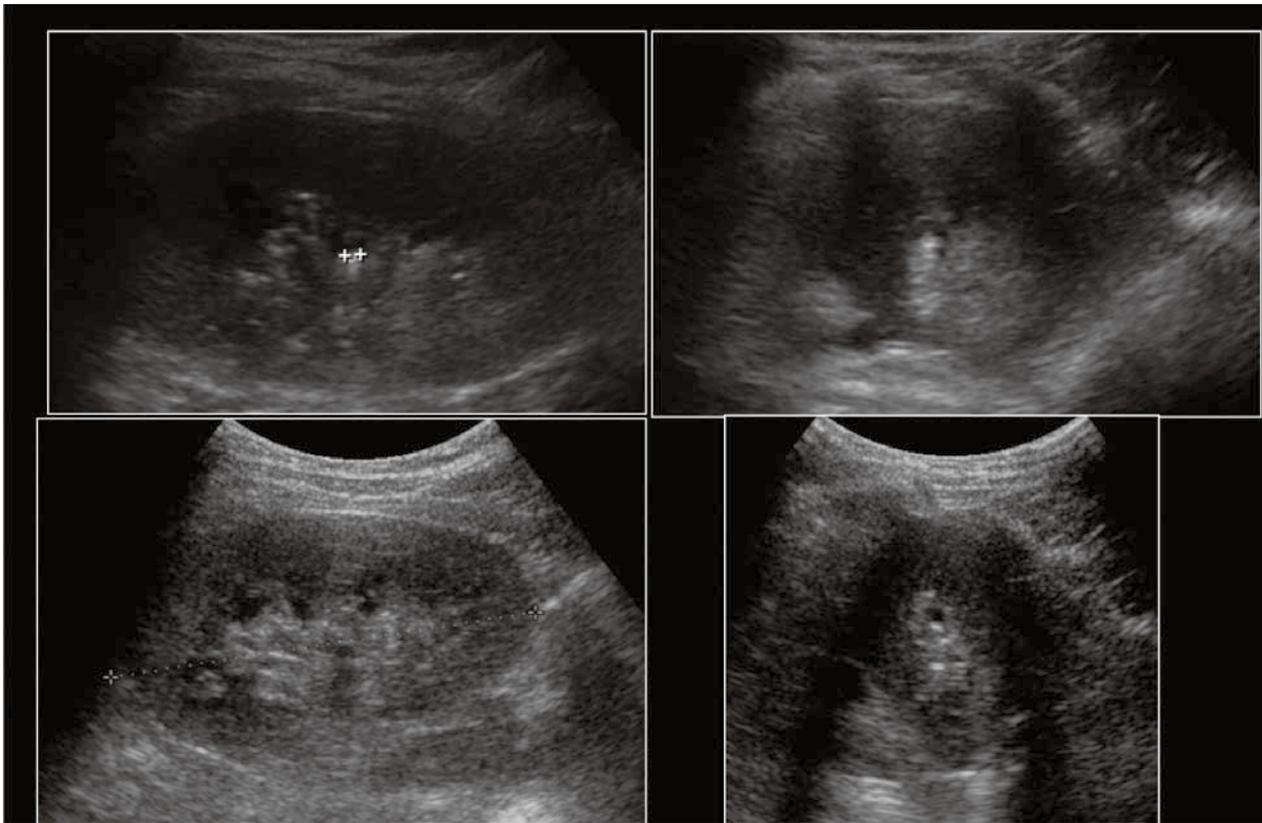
Ultrasonographic images showing a case of suspected renal deposit associated with MTMP. Note the small echogenic focus with comet tail artifact. Images on the top were from the initial examination with the follow-up images below.
